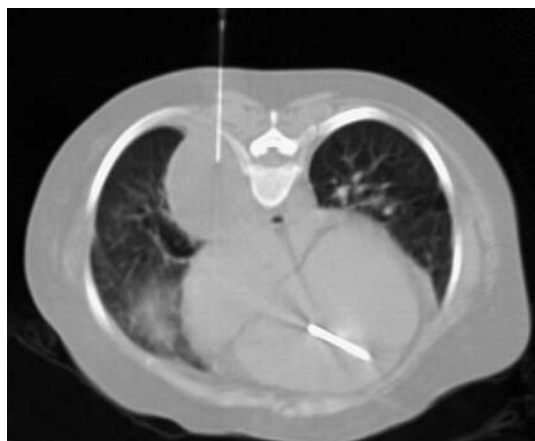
CT-guided percutaneous aspiration of a loculated effusion in a patient with tetralogy of Fallot
